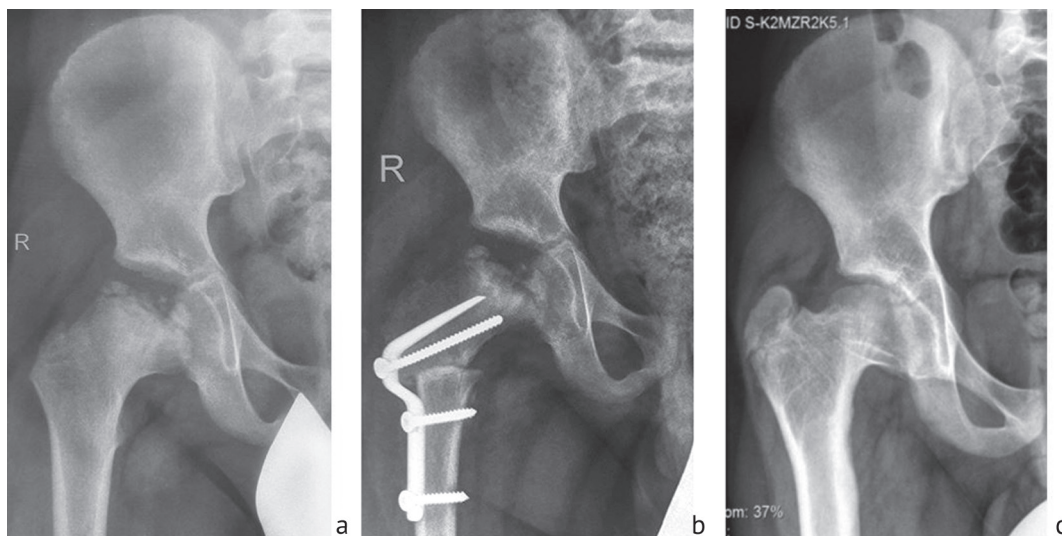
X-rays of the hip joints in patient R., 9 years old, right-side LCPD: *a* before surgery; *b* one months after varus osteotomy on the right side; *c* 4-year outcome of varus osteotomy on the right side
